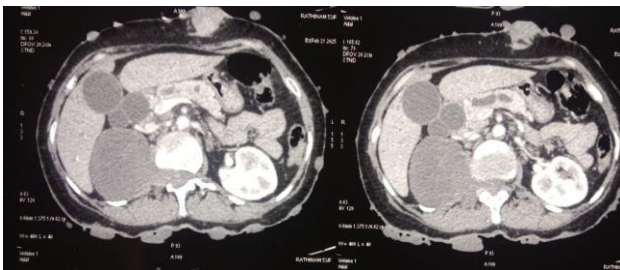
Contrast-enhanced CT of the abdomen.
